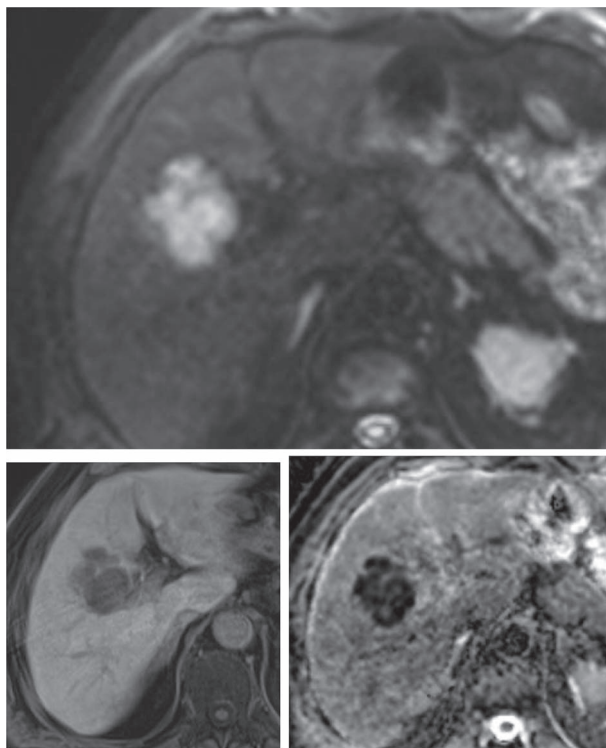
MRI of the liver with single poly-lobulated, smoothly delineated mass in the right liver lobe.
